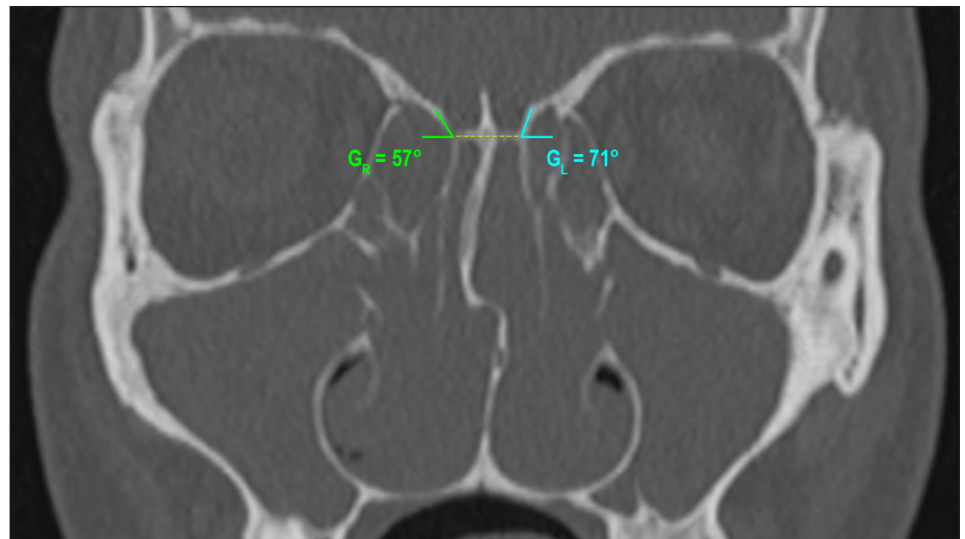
Paranasal sinus CT, coronal plane, bone window, at the level of the fronto-ethmoid angle, generated using the 3D MPR tool of Horos™ DICOM Viewer. The horizontal broken line corresponds to the level of the cribriform plate. This coronal slice shows the Gera classification. On the right side, the measured angle is 57° (GR) while on the left side, 71° (GL). Both angles are classified as Gera class II, or medium risk for iatrogenic injury. The Keros classification, as indicated by the depth of the olfactory fossa, is 2.4 mm on the right, or Keros type 1, and 4.4 mm on the left, or Keros type 2 (not shown in the image).
